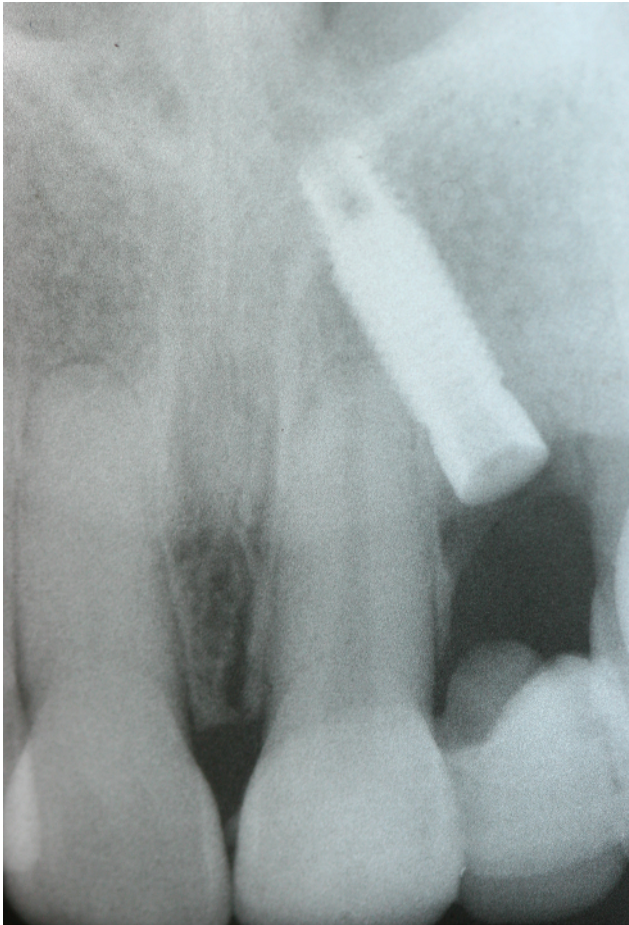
Periapical radiograph of malposed maxillary left lateral incisor implant.
